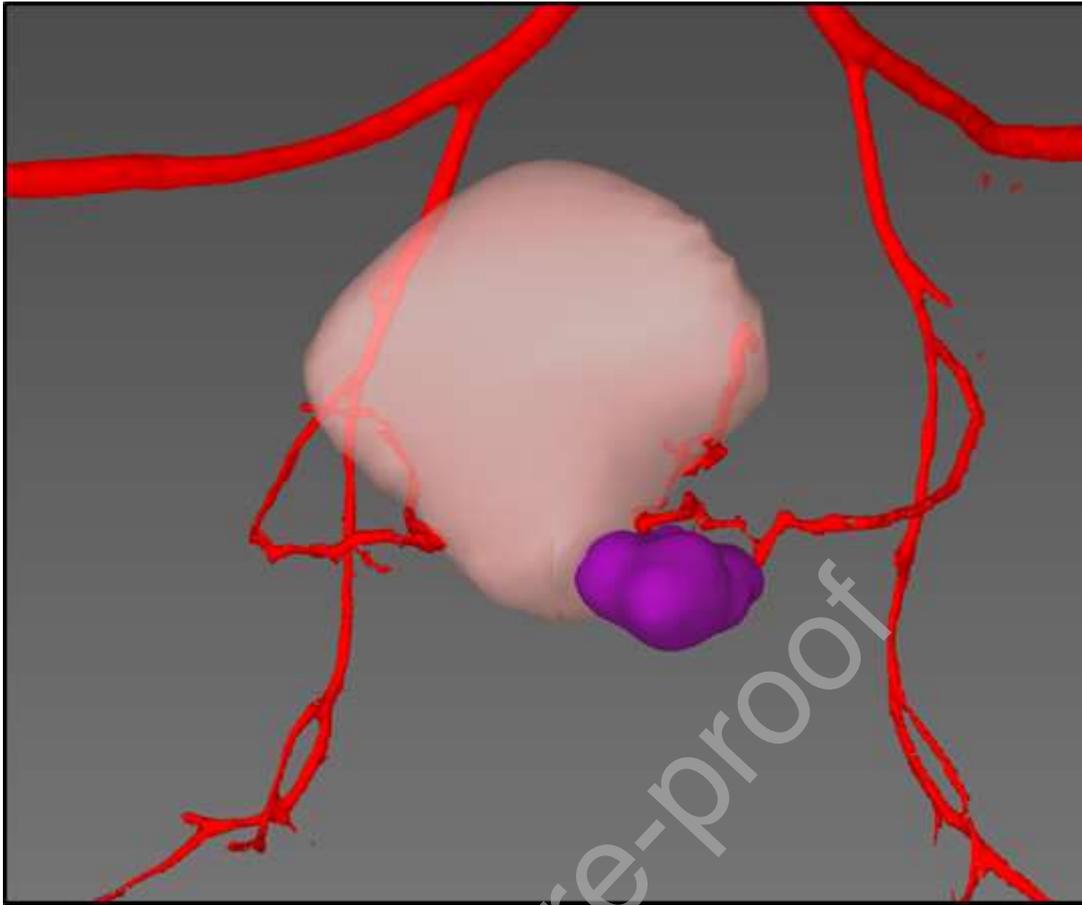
3D reconstruction from computed tomography angiography showing the relative position of the left uterine artery in relation to the remaining uterus and to the recurrence.
